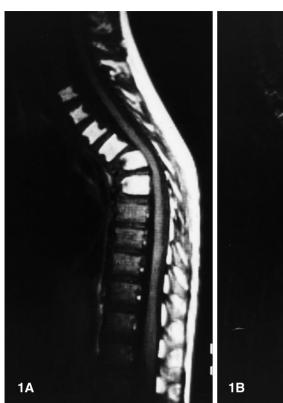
MRI of the thoracic spine at presentation. A T1-WSE scan (TR500/TE15) showing replacement of marrow of T2–T7 by tissue of high signal intensity, and a kyphosis centred on T6. B T2-WSE scan (TR2500/TE90) showing no appreciable change in signal intensity. Note absence of adjacent soft tissue mass
